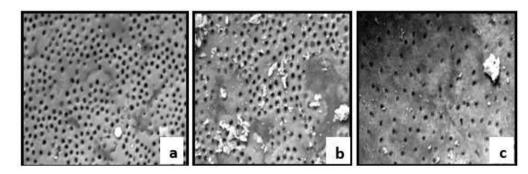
Group A – Chloroquick Solution with ultrasonic agitation; a) Coronal third; b) Middle third; c) Apical third
